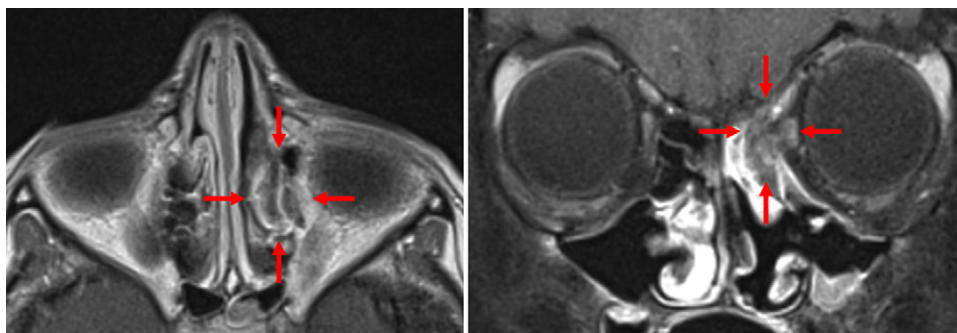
After 2 cycles of VIDE, MRI T1 sequences postgadolinium demonstrated a reduction of the mass. Maximum size was 2 cm × 0.8 cm × 1.9 cm.
